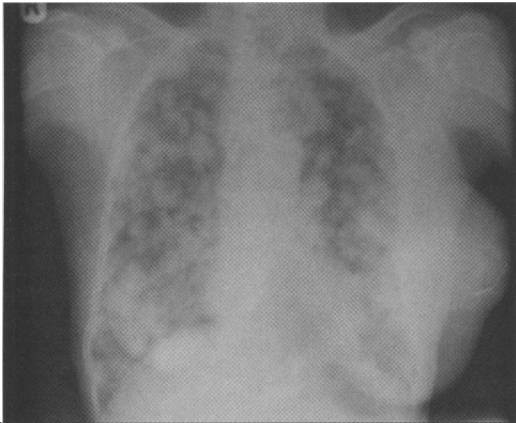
Chest x-ray of case 2 showing metastasis in both lung fields
